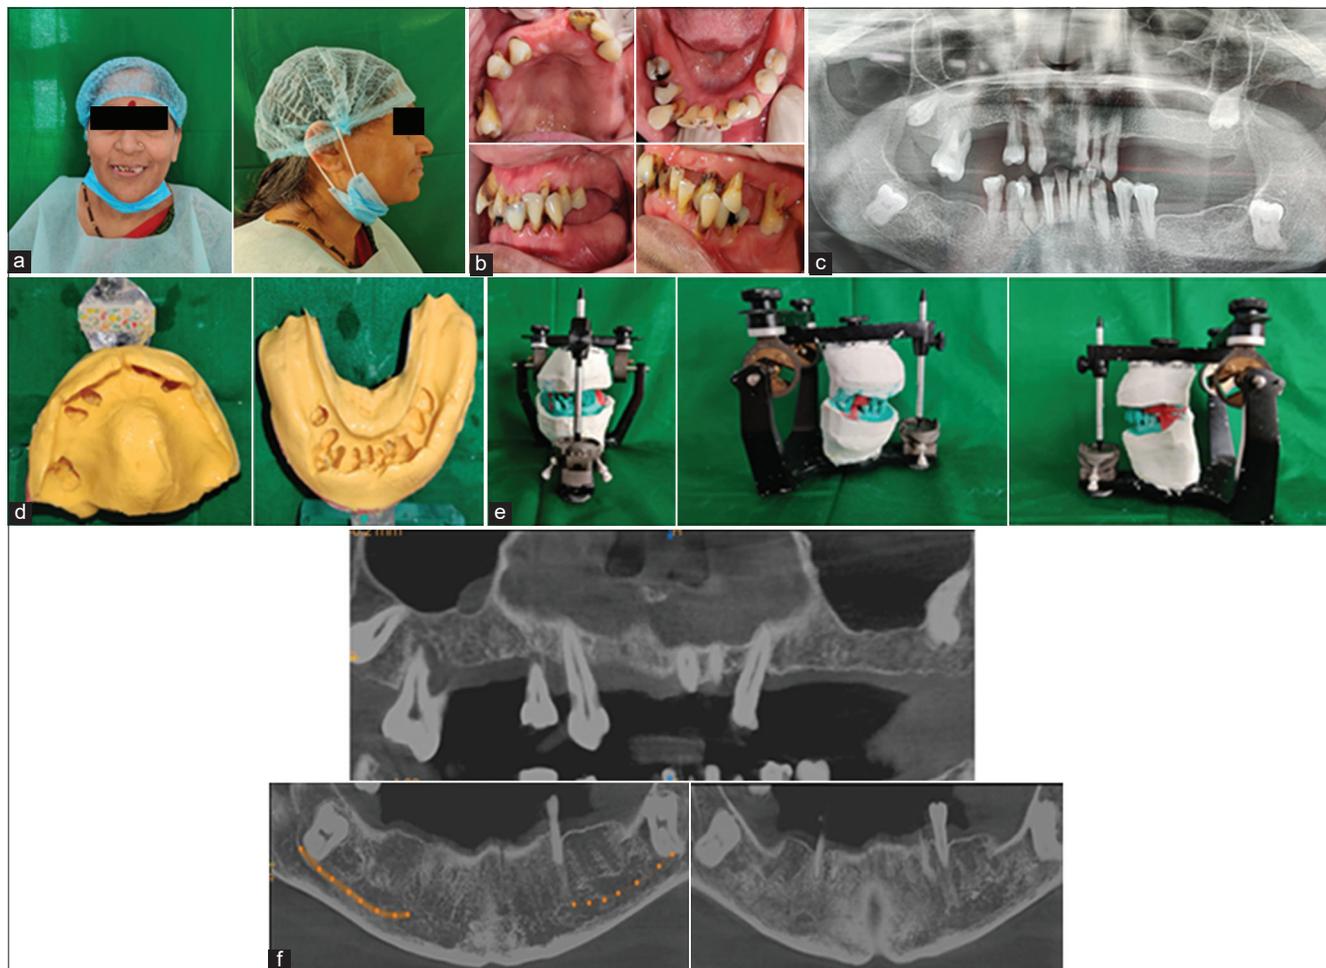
(a) Pre-treatment extraoral view, (b) pre-treatment intraoral view, (c) pre-treatment OPG, (d) diagnostic impressions, (e) diagnostic mounting, and (f) CBCT analysis.
